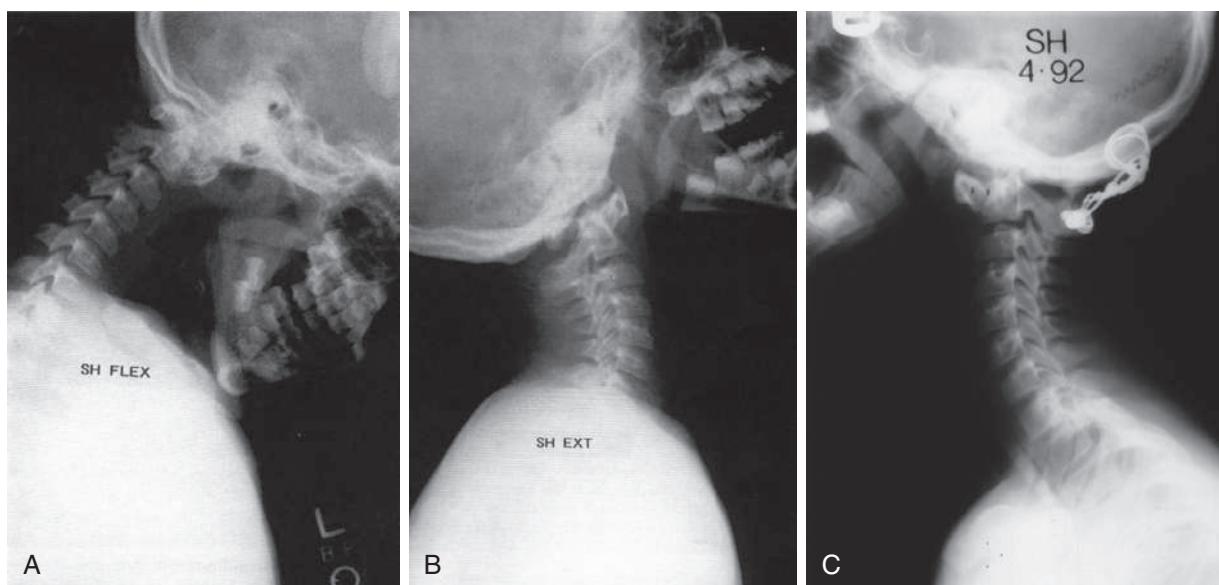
Flexion (A) and extension (B) radiographs of a case of Down syndrome demonstrating atlanto-occipital hypermobility and subluxation. C, Instability and symptoms were relieved by an occipitoaxial arthrodesis.
